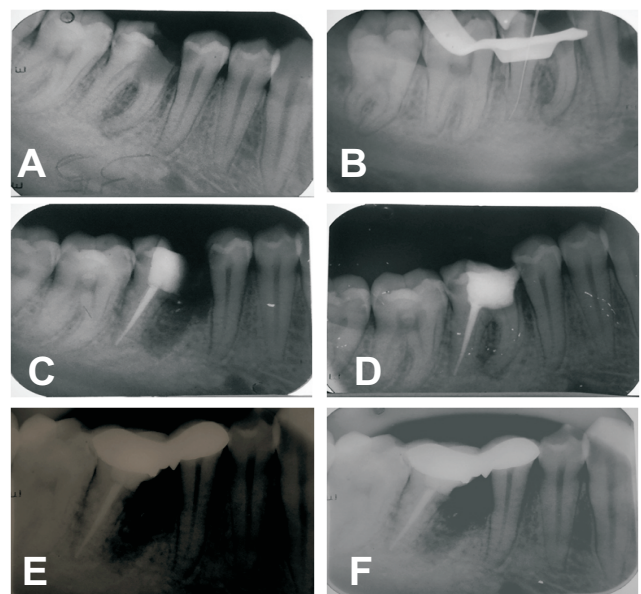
(A) Preoperative radiograph showing the extent of carious lesion and periapical radiolucency. (B) Working length estimation. (C) Radiograph after completion of obturation.(D) Radiograph after hemisection. (E) 3- month follow-up. (F) 9-month follow-up showing healing of bone.
